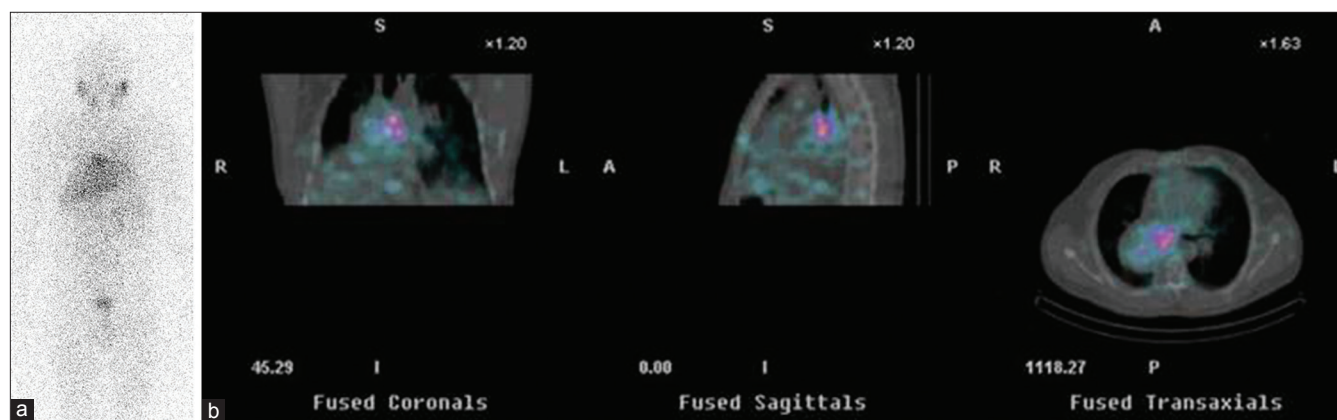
(a) The ^{131}I -MIBG planar images at 48 h reveal tracer uptake in the right side of chest; (b) SPECT/CT images of the same patient show a focal tracer activity in the right paracardiac region, suggesting the presence of right paracardiac NET
